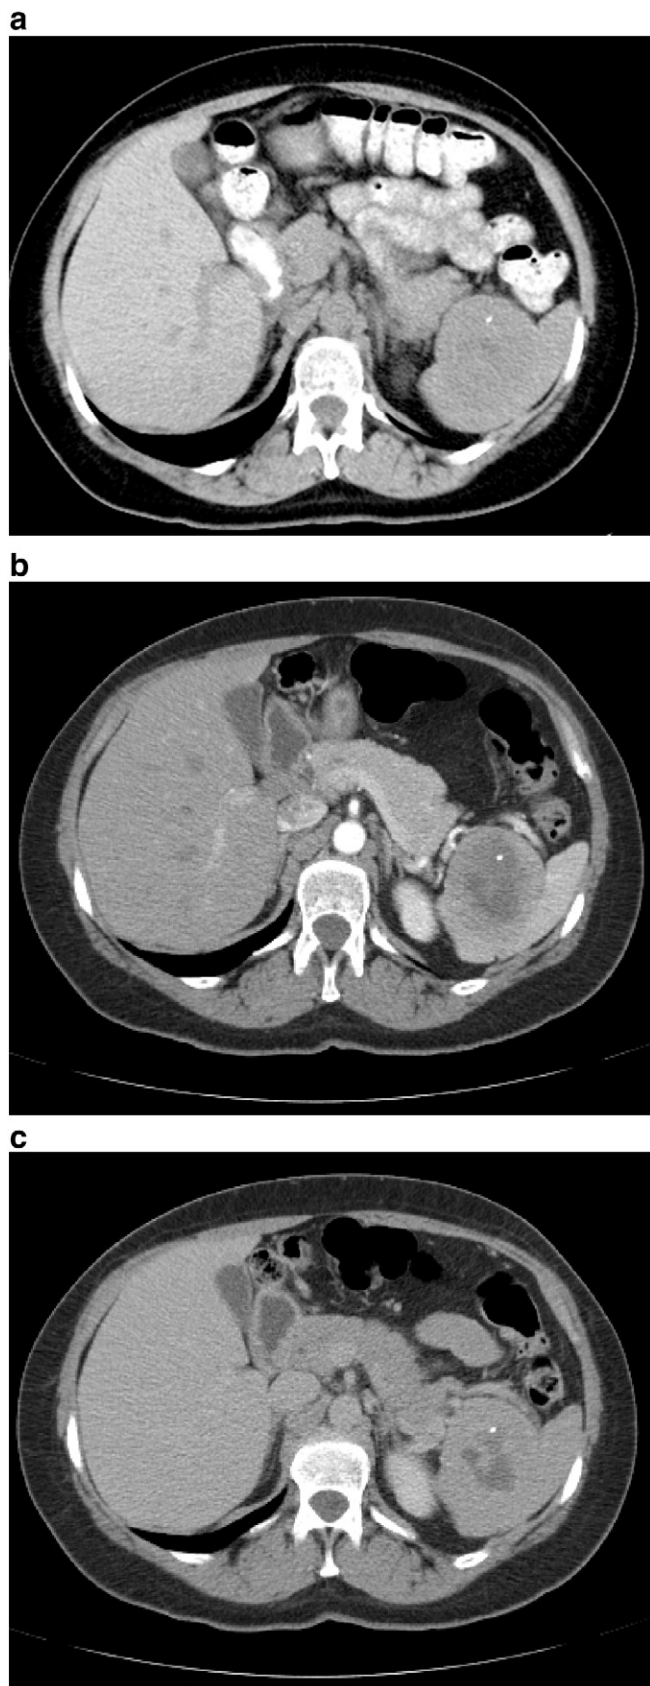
(a–c): Axial CT of the abdomen shows a round, exophytic, splenic mass with a small internal calcification. The mass is nearly isoattenuating on precontrast imaging (a) with progressive enhancement from the late arterial (b) to the delayed phase (c).
